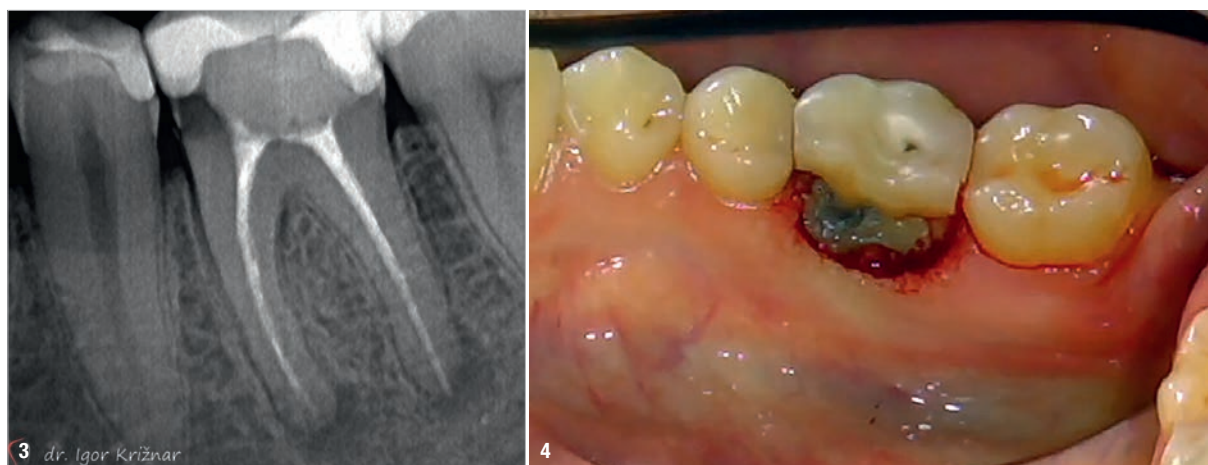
Radiograph of tooth #36 before crown lengthening and endodontic treatment. Fig. 4: Tooth #36 immediately after crown lengthening.
